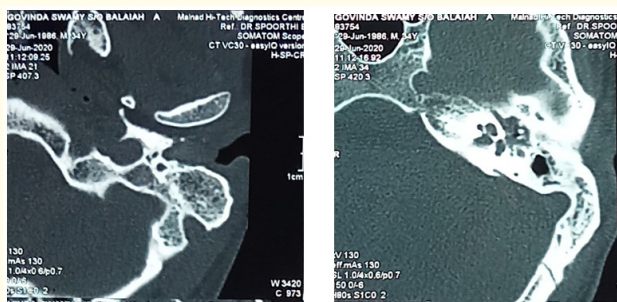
HRCT images of the left ear.
